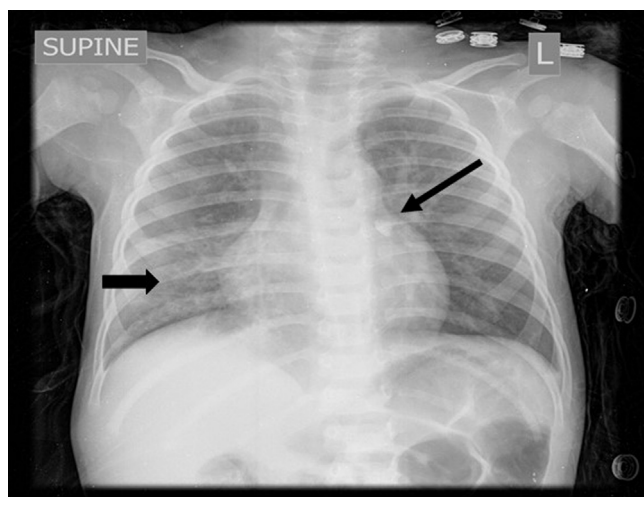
Chest radiography showing right lower lobe interstitial markings (*thin arrow*) and a calcified left perihilar nodule projecting to the left main bronchus (*thick arrow*).
